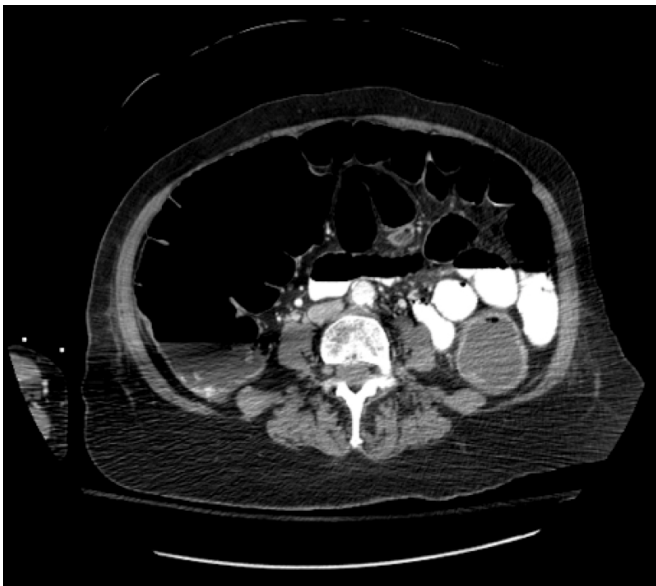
CT scan of Patient 1 revealing colonic distension with no evidence of mechanical obstruction
